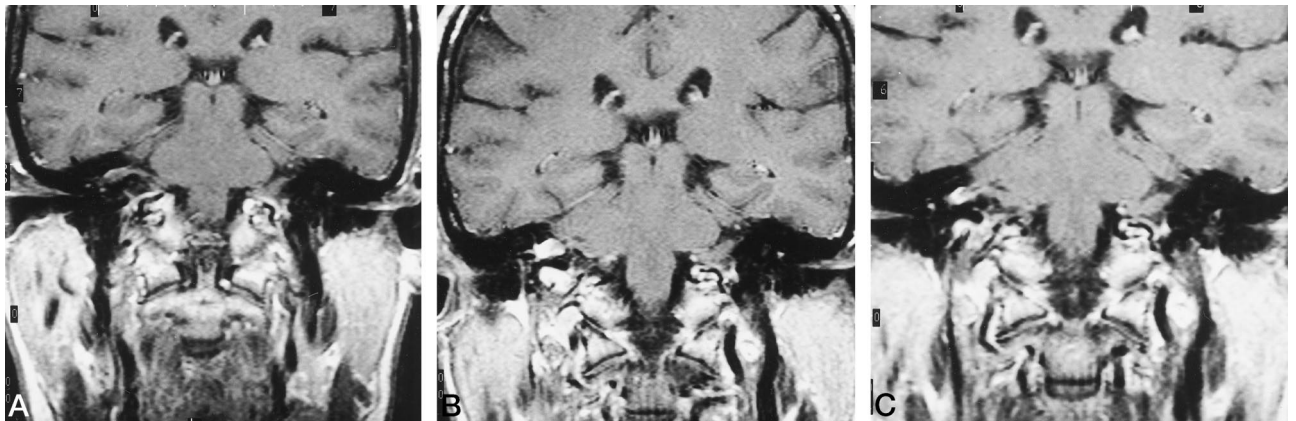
Contrast-enhanced coronal T1-weighted MR images after resection of an acoustic neuroma show changes in enhancement at the postoperative site.
